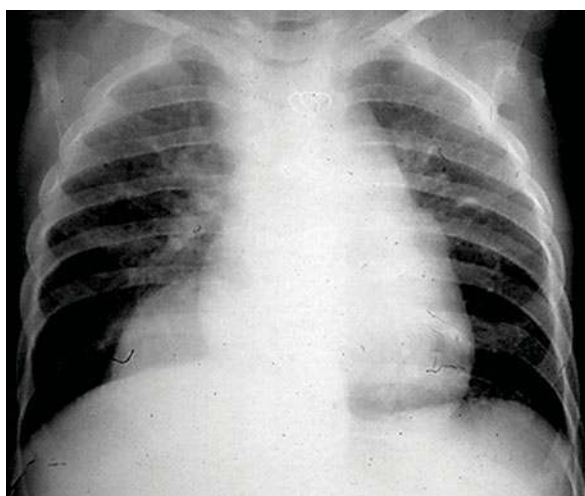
A 2-year-old boy with a sequester. Chest radiograph shows a large mass close to the spine in the lower right lung
